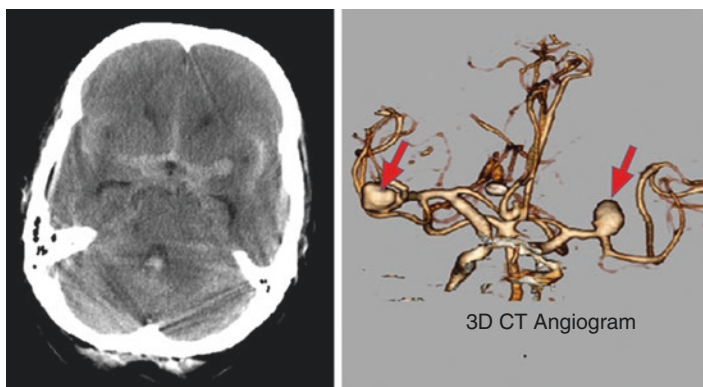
Non-contrast CT scan showing subarachnoid hemorrhage and a 3D CT angiogram showing multiple aneurysms (Left and right middle cerebral artery aneurysms {red arrows}—round blebs on the arterial tree like pumpkins and an ACOM aneurysm {not arrowed})
